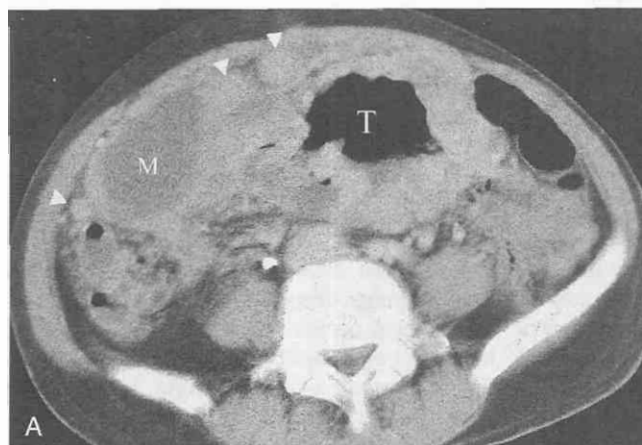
Leiomyosarcomatosis and hepatic metastasis in a malignant gastrointestinal stromal tumor of the jejunum. A, CT scan shows a large, exophytically growing cavitary mass (T) in the jejunum. Note multiple peritoneal nodules (arrowheads). B, CT scan shows a large hepatic metastatic lesion (M) and peritoneal nodule (arrows) in the omentum.
